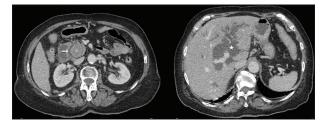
Computed tomography scan: axial slices showing a large calculus in the common bile duct (arrow) and dilatation of the extrahepatic and intrahepatic (asterisk) bile ducts
